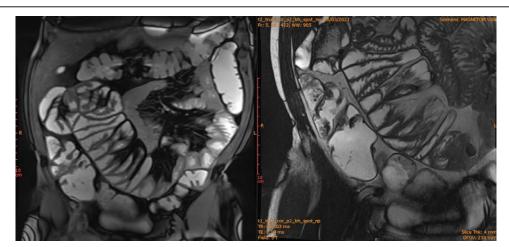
MRI findings, showing a part of small bowel trapped in the right peritoneal cavity.
